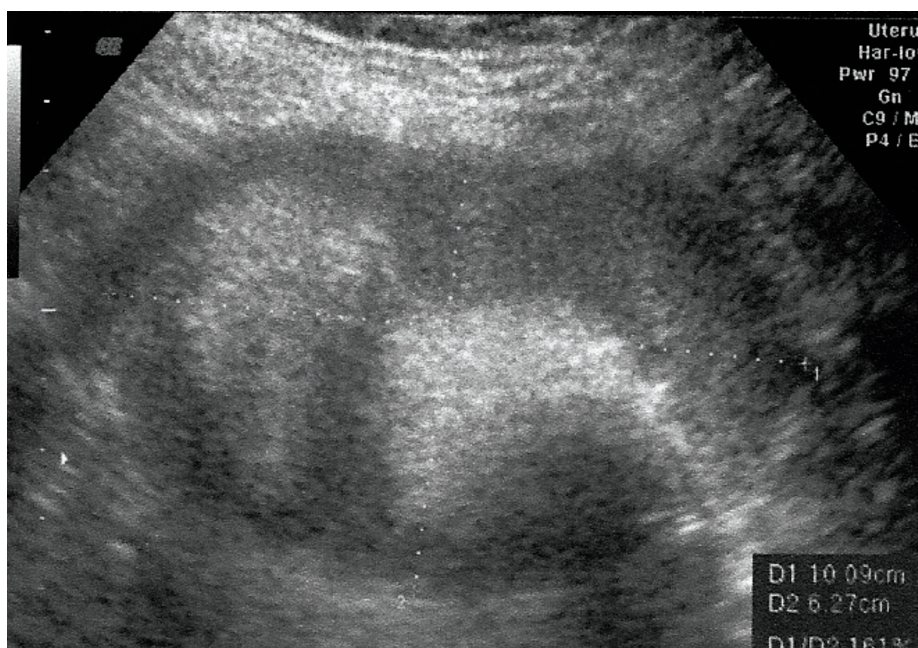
Transabdominal ultrasound of pelvic mass.
